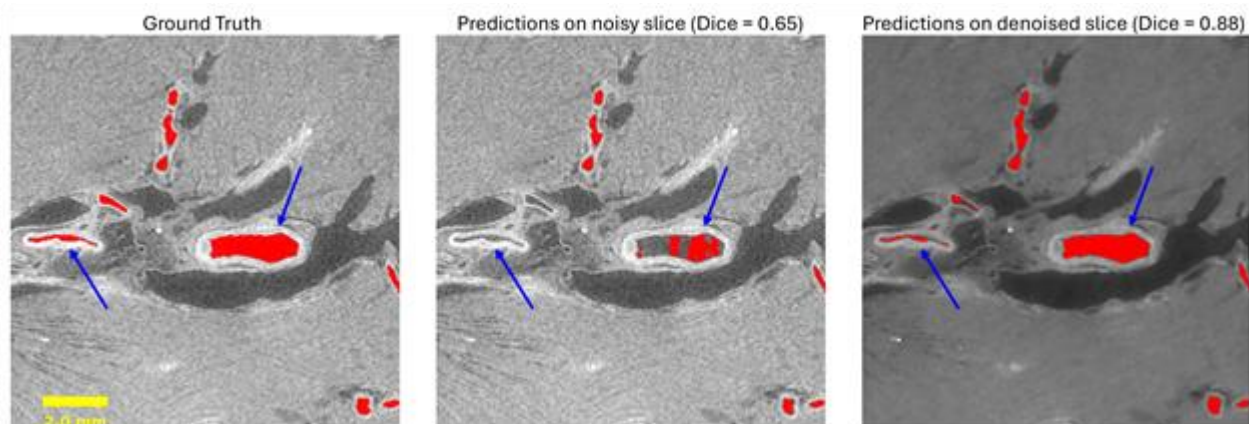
Blood vessel segmentation comparison on HiP-CT Kidney scan. Blue arrows highlight better segmented blood vessels in the denoised image.
